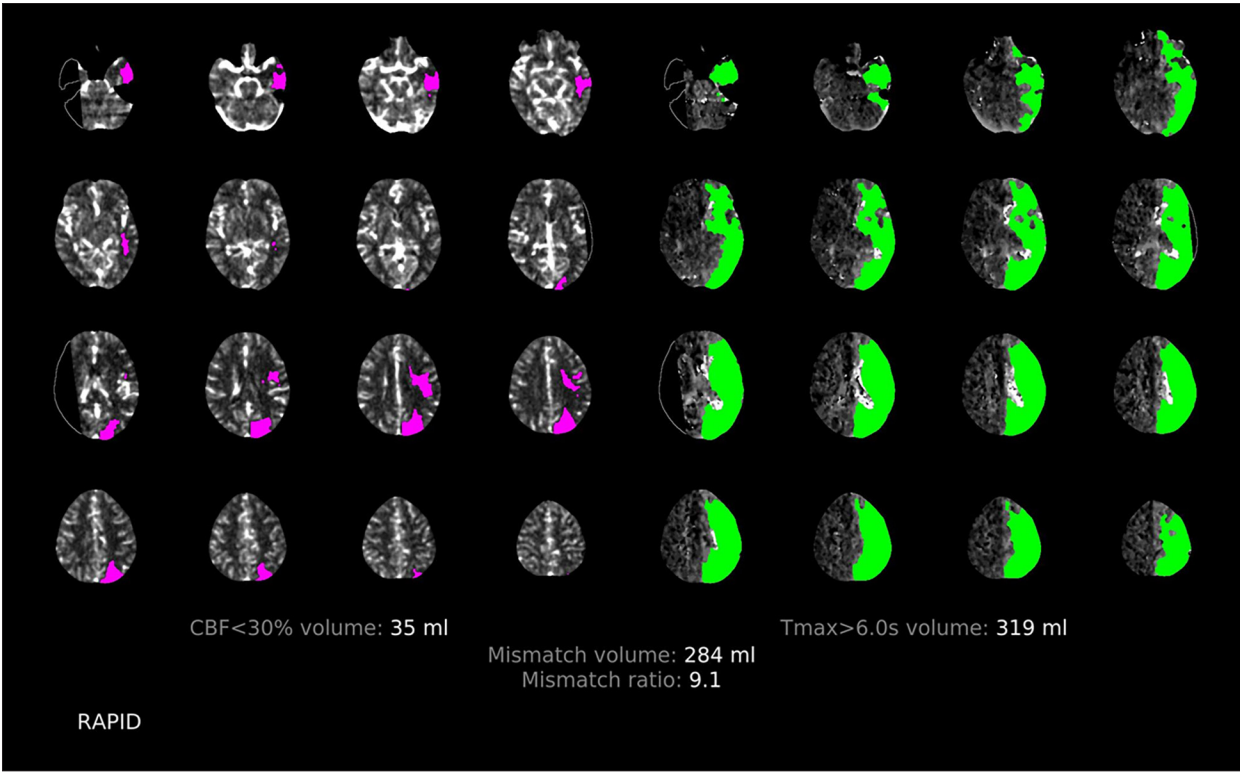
Computed tomography perfusion imaging demonstrating extensive regions of prolonged mean transit time and time to maximum (Tmax) in the left cerebral hemisphere. Corresponding regions showed decreased cerebral blood volume (CBV) and cerebral blood flow (CBF). The volume of CBF < 30% was approximately 35 mL, volume of Tmax > 6 seconds was approximately 319 mL, mismatch volume was approximately 284 mL, and mismatch ratio was 9.1. The hypoperfusion intensity ratio (Tmax > 10 seconds/Tmax > 6 seconds) was 0.6, and the CBV index (relative CBV within the Tmax > 6 seconds region) was 0.8.
